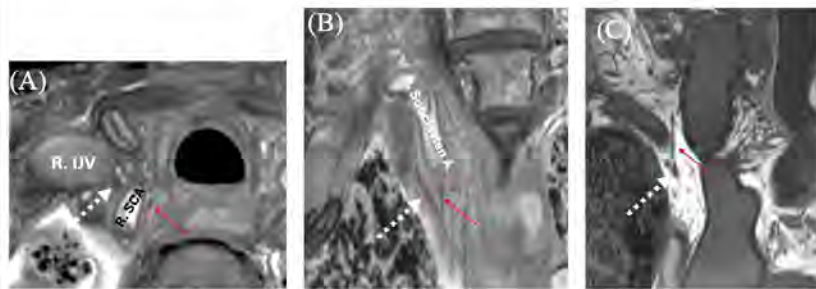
(A) Axial MPR of CISS MRI showing right Recurrent laryngeal Nerve (RLN) (red arrow) going around the right subclavian artery; (B) Coronally reformatted CISS image of right RLN as it branches off the main trunk of CN X below the right subclavian artery; (C) Coronally reformatted CISS image of right RLN as it branches off the main trunk of CN X below the right subclavian artery; main trunk of CN X (dotted white arrow);
